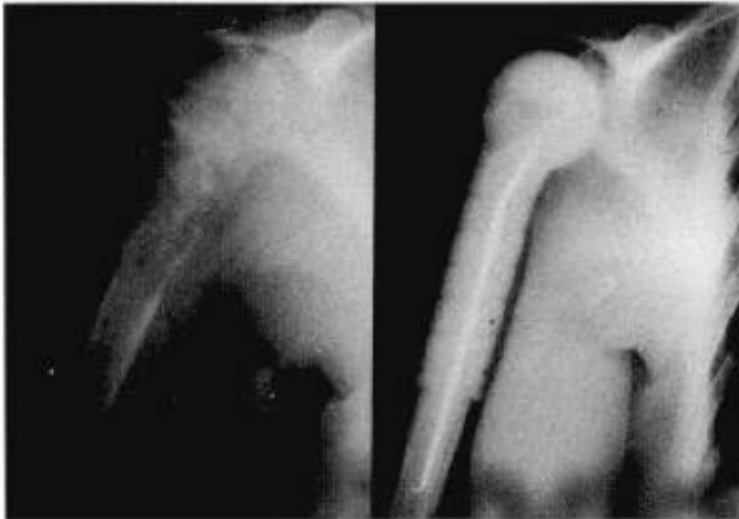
Preoperative anteroposterior radiograph of Ewing's sarcoma of the proximal one-third of the right humerus, and postoperative control after resection and replacement with an endoprosthesis.
